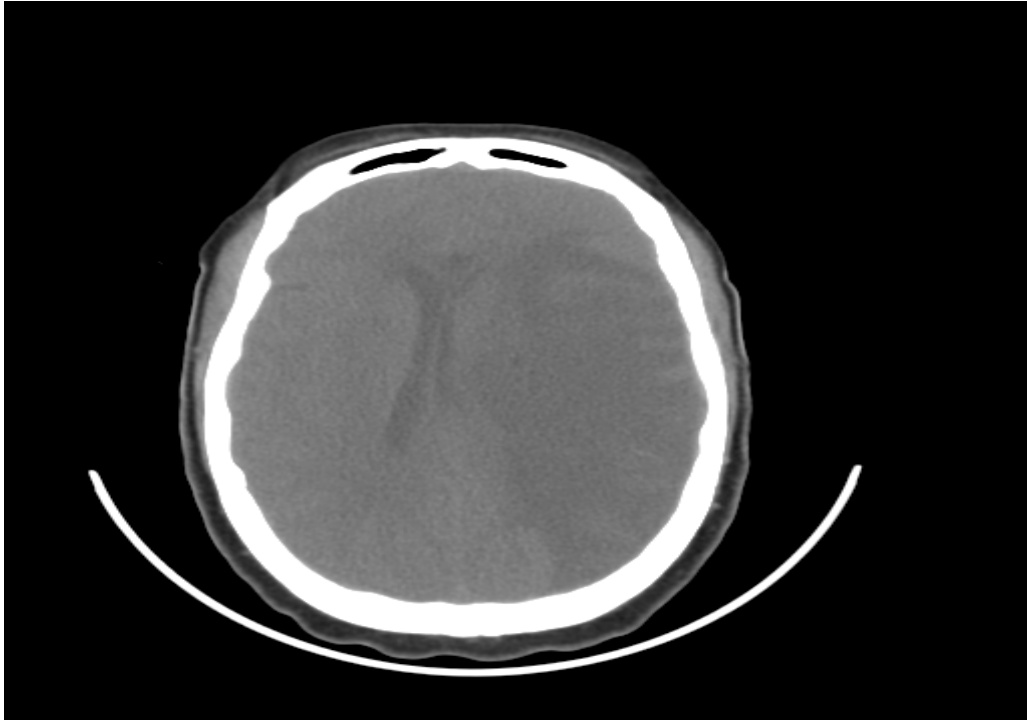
Brain CT of an extensive hypointensity in Middle Cerebral Artery with cortical involvement
